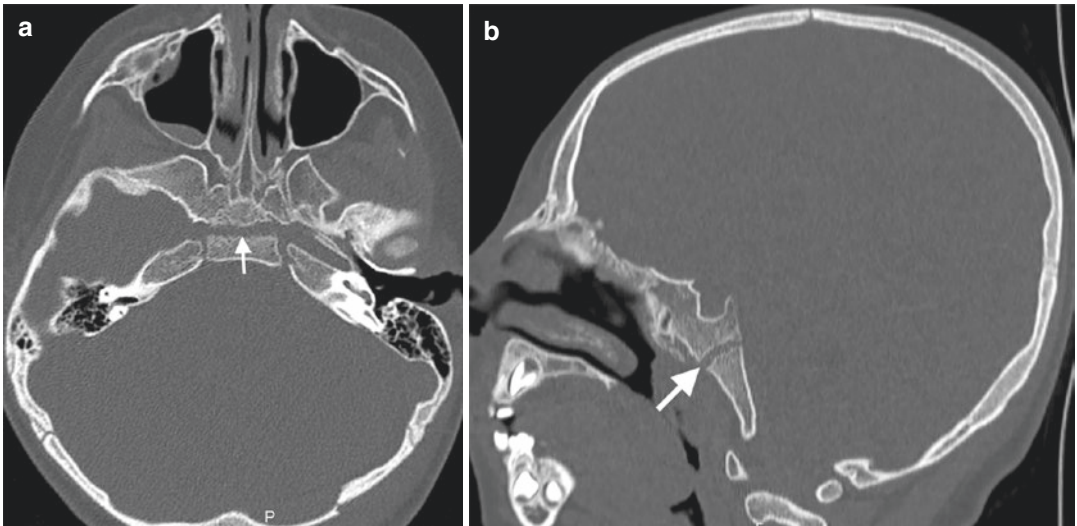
Sphenooccipital synchondrosis. Axial (a) and sagittal (b) CT images reveal sphenooccipital synchondrosis (arrows) mimicking clivus fracture
